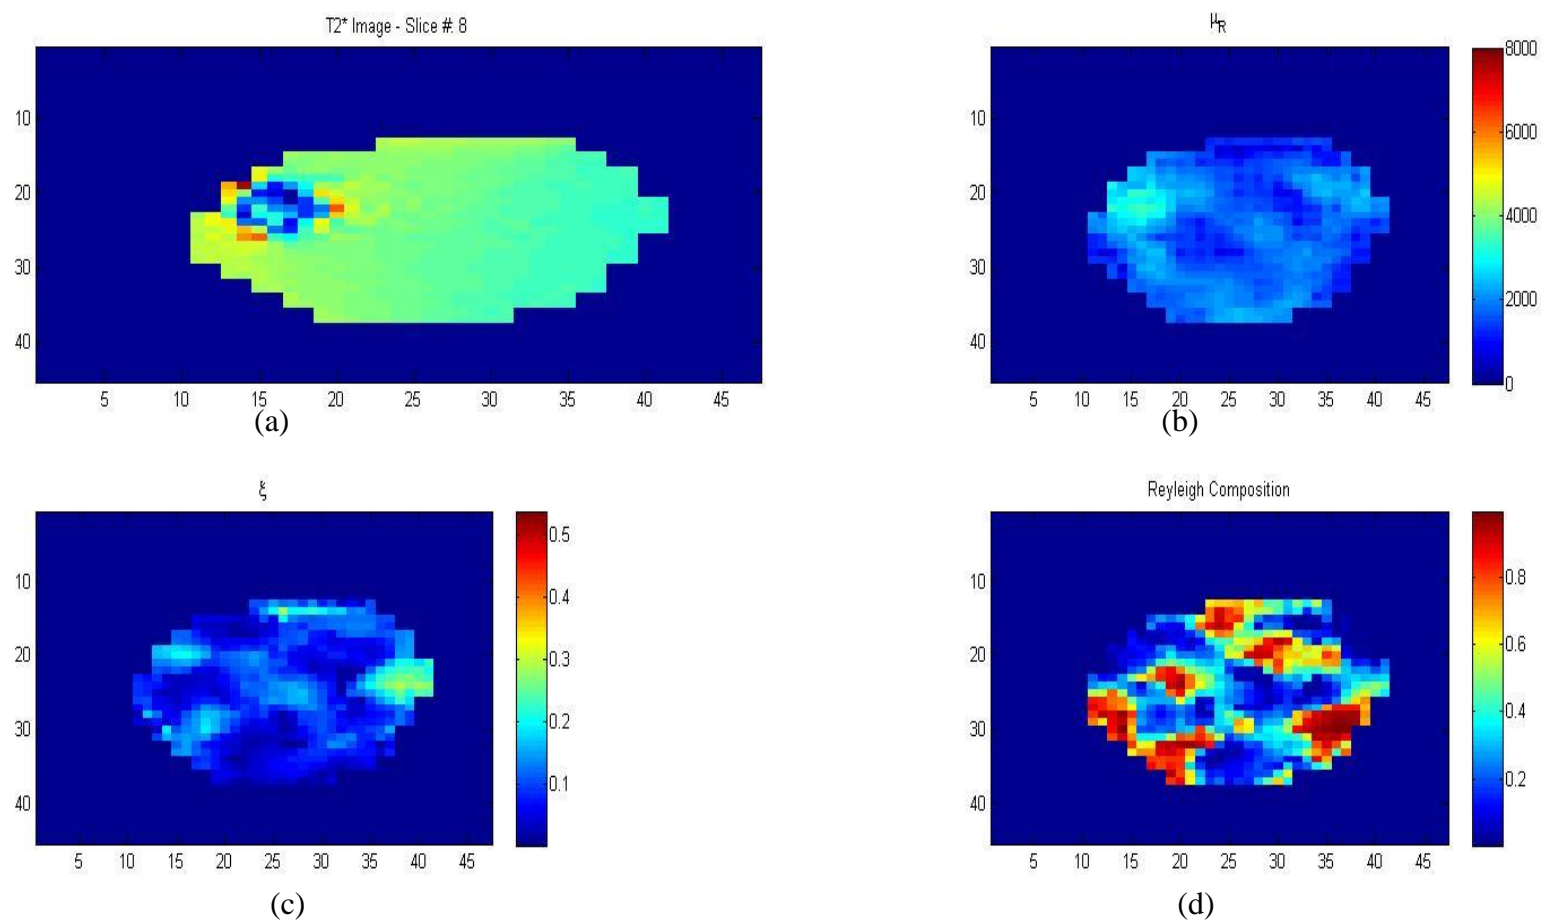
Reconstruction of Case 1(slice 8) (a) MR image, (b) Shear modulus reconstruction, (c) Damping ratio reconstruction and (d) Rayleigh composition.
